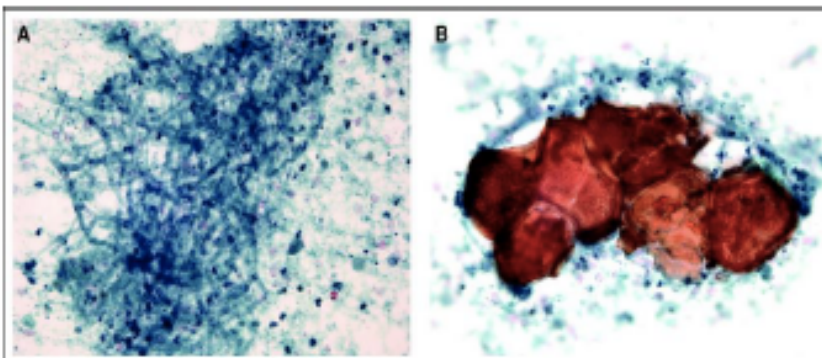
A CT-guided fine-needle aspirate of the cavity revealed necrosis, inflammation, and masses of hyaline fungal hyphae with dichotomous branching and septations, compatible with *Aspergillus* species.
